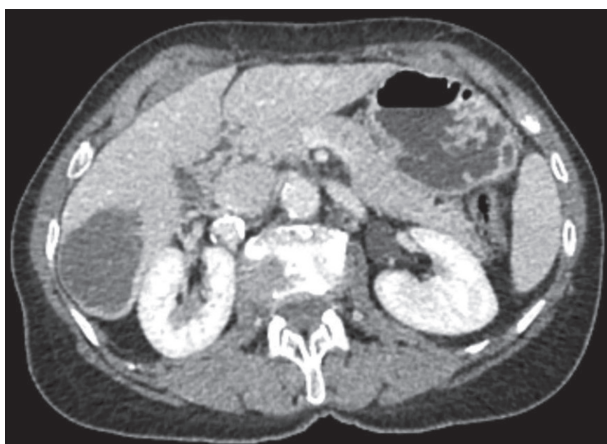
Abdominal computed tomography scan showing a hydatid cyst in segment VI of the liver
